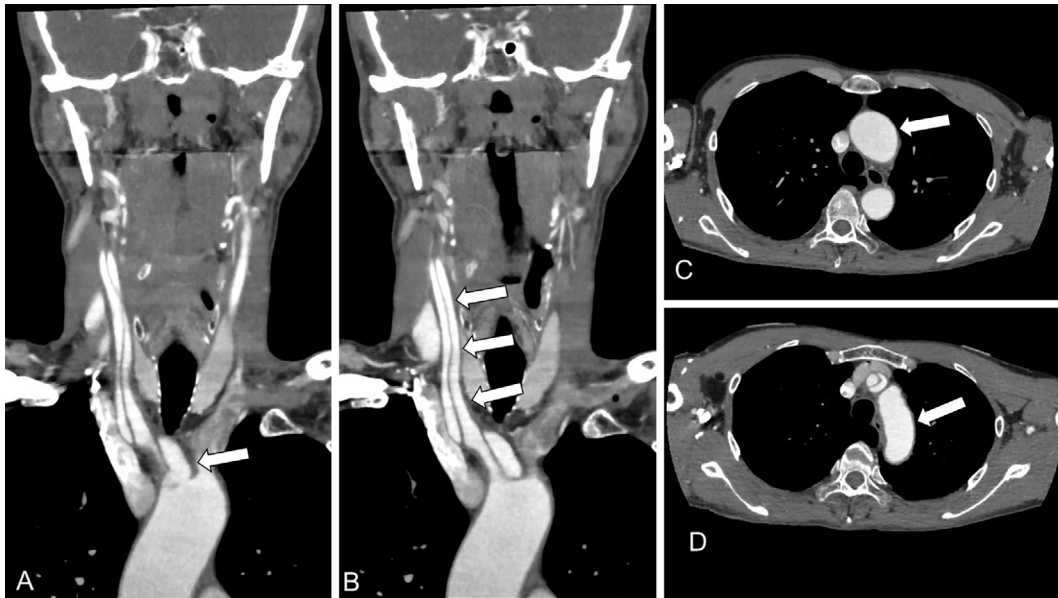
Initial contrast-enhanced CT of the neck and chest. Coronal images showing arterial dissection extending from the brachiocephalic artery (A, arrow) to the right CCA (B, arrows). The true lumen (B, arrows) is seen in the arterial dissection. Axial images showing no findings suggestive of aortic dissection in the ascending aorta (C, arrow) or aortic arch (D, arrow). CT: computed tomography, CCA: common carotid artery
